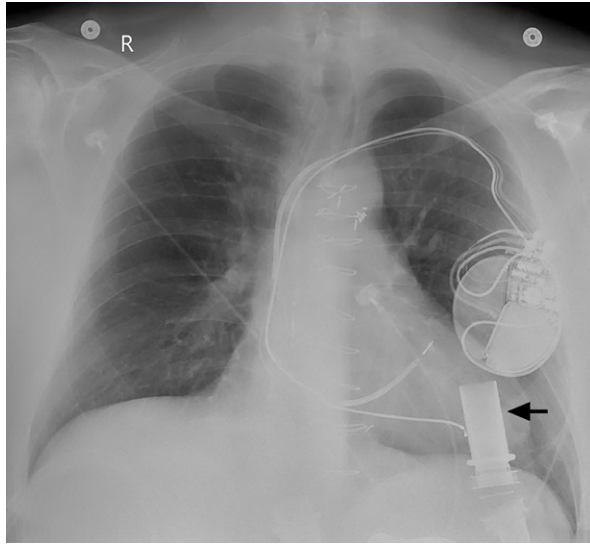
Chest radiograph shows malposition of the left ventricular assist device inflow cannula (arrow). In correct position, the inflow cannula would be directed toward the mitral valve; here, it faces the anterolateral wall of the left ventricle, causing device malfunction.
